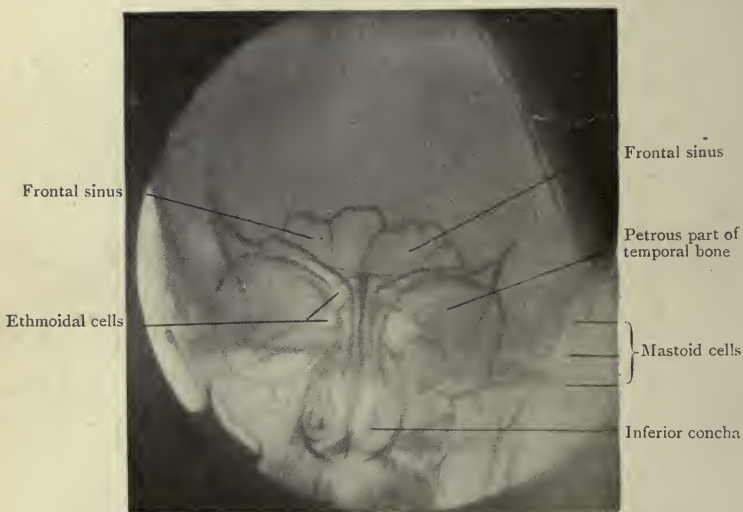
Antero-posterior radiograph of Skull, showing large frontal sinuses.
